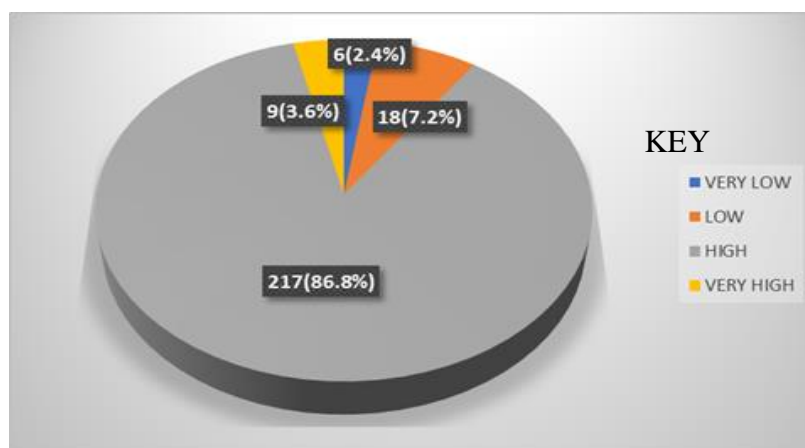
Distribution of obstetric ultrasonography expectations score category (n=250).
